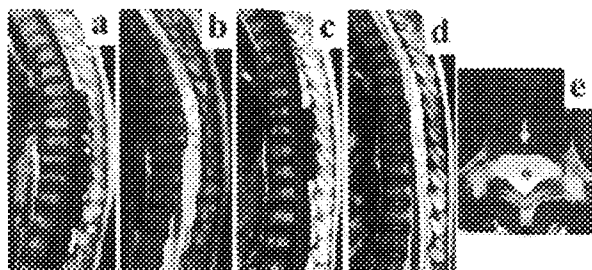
MRI of family members with spinal extradural arachnoid cysts. Sagittal planes of the thoracolumbar spine (a–d) showing multiple cysts dorsal to the spinal cord in the proband (III-5, a and b) and in III-2 (c and d). a and c: T1 weighted image; b and d: T2 weighted image. Axial plane (T2 weighted image) at T10/T11 disc level in III-5 (e) showing expanding of the cyst within the spinal canal. Arrow and asterisk depict spinal cord and extradural arachnoid cyst, respectively.
